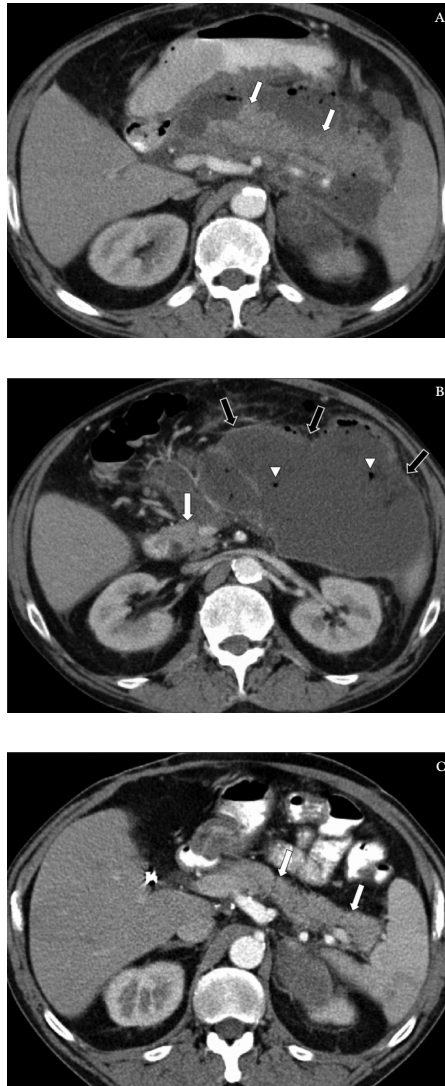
(A, B) Contrast-enhanced CT of a patient with acute pancreatitis 22 days after onset of symptoms. There is normal enhancement of the body and tail of the pancreas, surrounded by a large heterogeneous and encapsulated fluid collection with gas bubbles suggestive for secondary infection.
